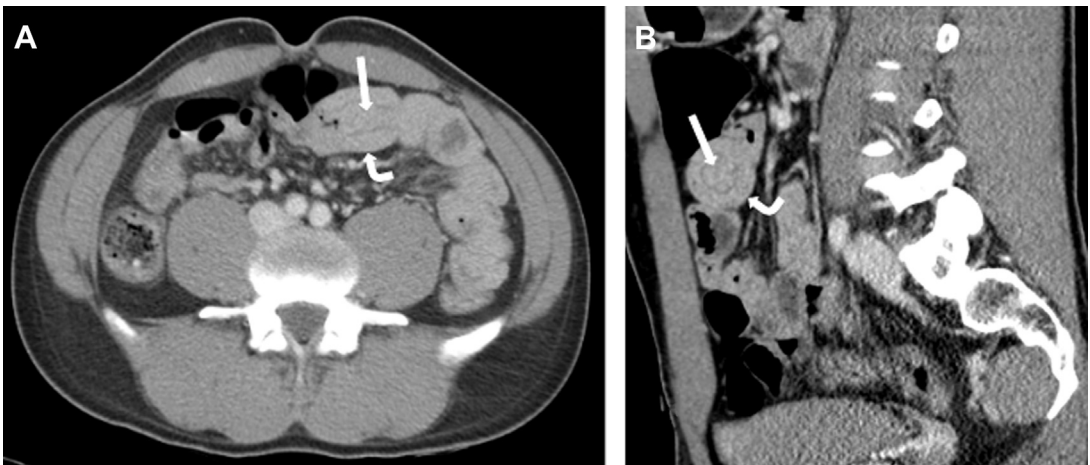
Transient intussusception. A 32-year-old man with acute abdominal pain. Axial (A) and sagittal (B) images from CT performed with intravenous and without oral contrast, show an entero-enteric intussusception with the classic bowel in bowel appearance of the intussusceptum (*straight arrows*) within the receiving segment of small bowel, referred to as the intussusciens (*curved arrows*). This is a short segment intussusception without evidence of pathologic lead point, bowel obstruction, or inflammation. Therefore, findings are highly suggestive of a benign transient intussusception, a self-limiting condition. On follow-up CT 1 week later (not shown), the intussusception had resolved.
